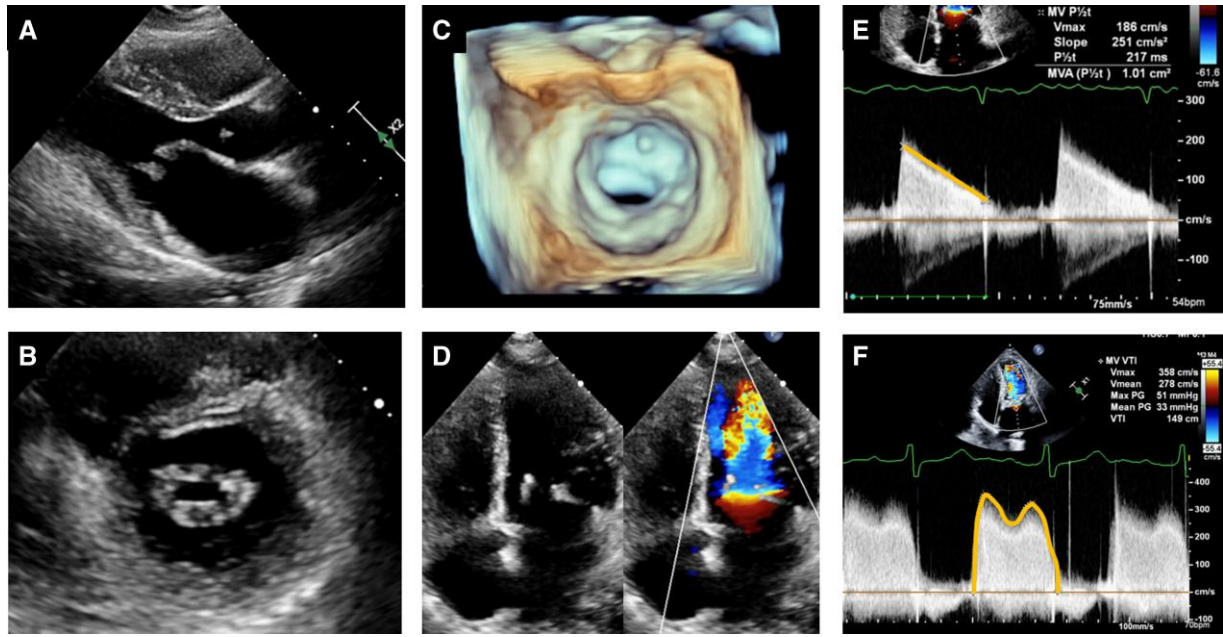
Echocardiographic findings in severe rheumatic mitral stenosis. 'Hockey-stick' deformity with mitral valve leaflet thickening, commissural fusion and flow acceleration on colour Doppler imaging (A–D). Continuous-wave Doppler demonstrating pressure half-time method for assessment of mitral valve area (E) and mean mitral valve gradient (F).
